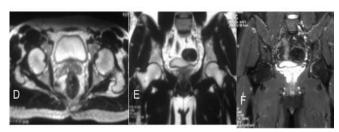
(A) -Plain Radiograph of Pelvis Is Unremarkable.
